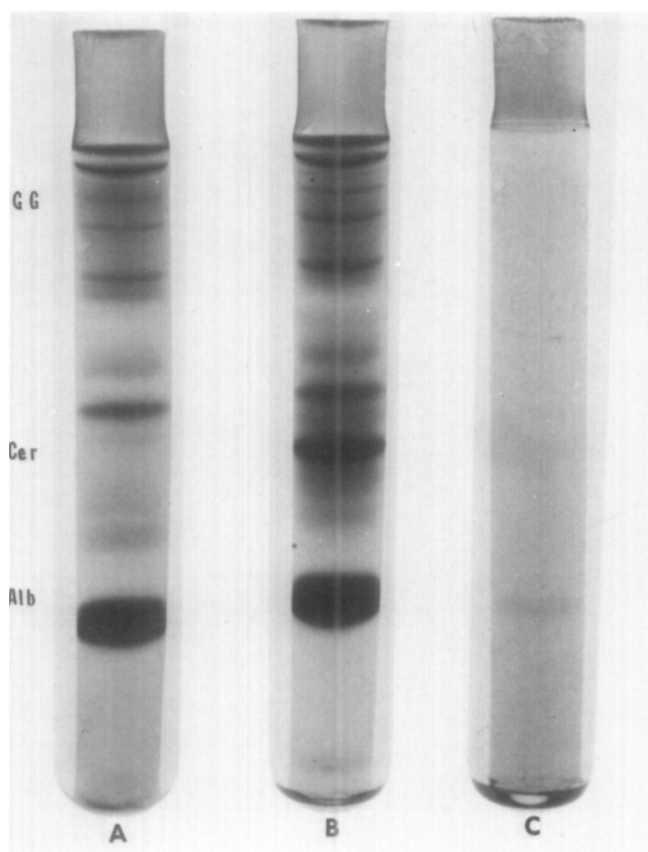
Polyacrylamide-gel electrophoretic patterns from Case 24; periapical granuloma. *A*, Fingertip plasma. *B*, Periapical plasma. *C*, Root canal fluid. *Alb*, Albumin; *Cer*, ceruloplasmin region; *GG*, gamma globulin region.
